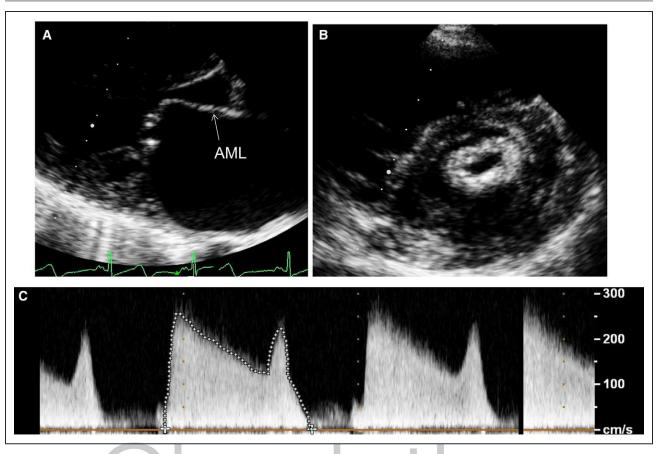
Two-dimensional echocardiography for rheumatic heart disease and mitral stenosis.
